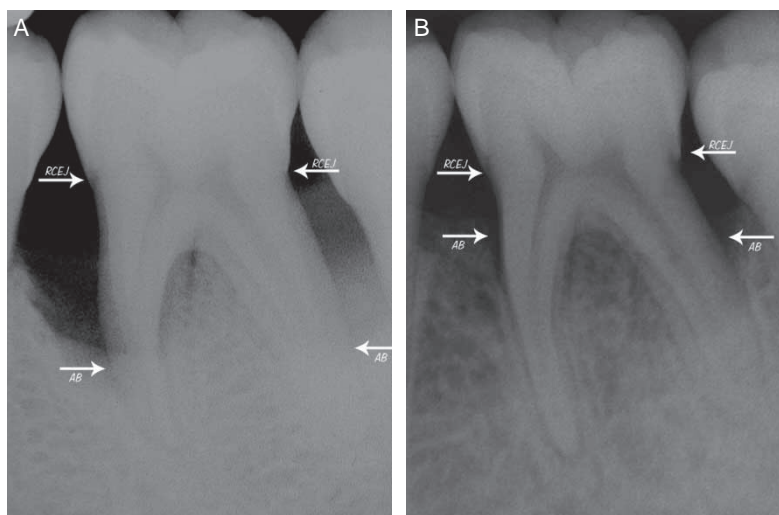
Radiographic appearances of the defects (RCEJ: radiographic cemento-enamel junction, AB: alveolar bone). A. Before treatment of BG/GTR. B. After treatment of BG/GTR.
